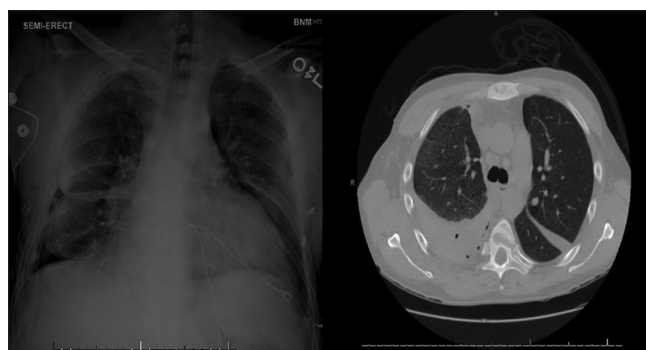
X-ray image on the day of surgery, CT chest image at the level of carina with no obstruction 2 days before surgery
